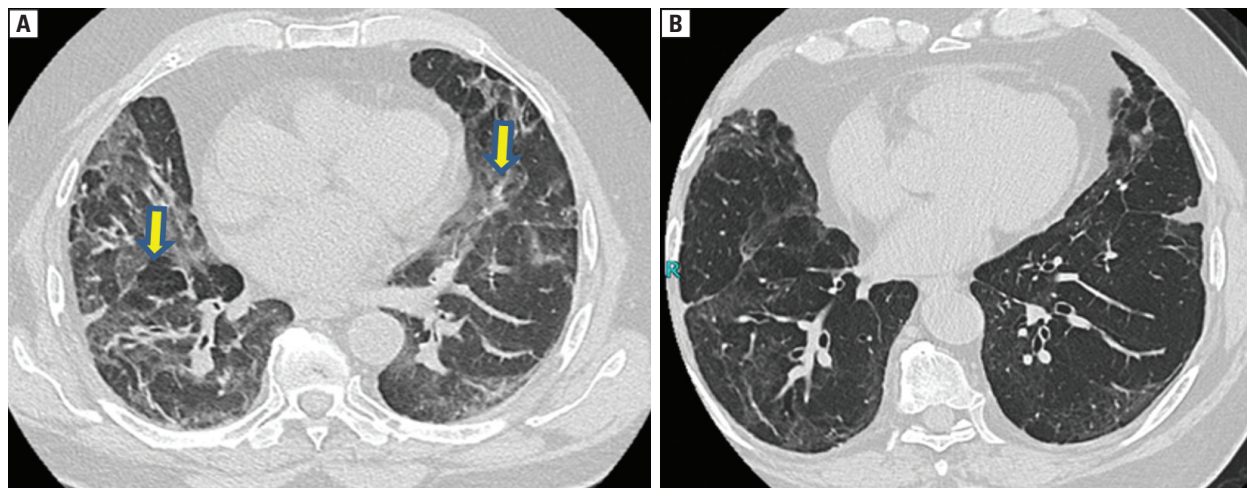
HRCT of the chest showing A. ground glass opacities (GGOs) and interlobular septal thickening (yellow arrow showing GGOs and septal thickening); and B. interval reduction in GGOs and septal thickening after initiation of corticosteroids
